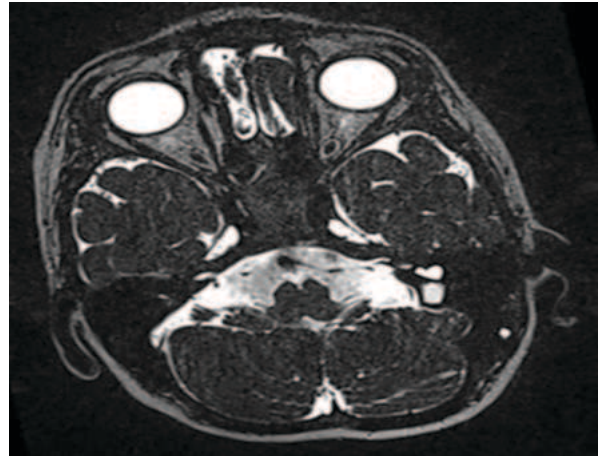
Axial T2W MR image showing small IAC.
